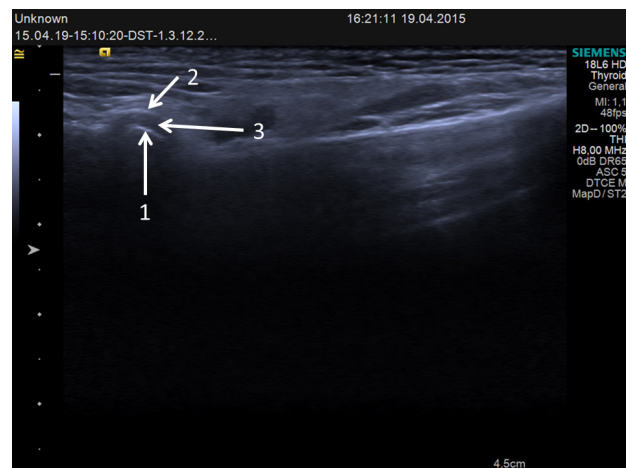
Ultrasonographic view of TMJ shows condyle (arrow 1), articular eminence (arrow 2) and articular disc (arrow 3).
